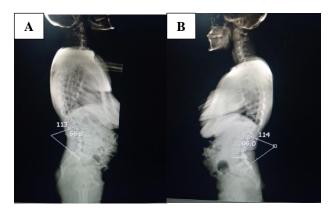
A) Pre and B) postoperative radiographic measurement of lumbar lordosis (LL).
